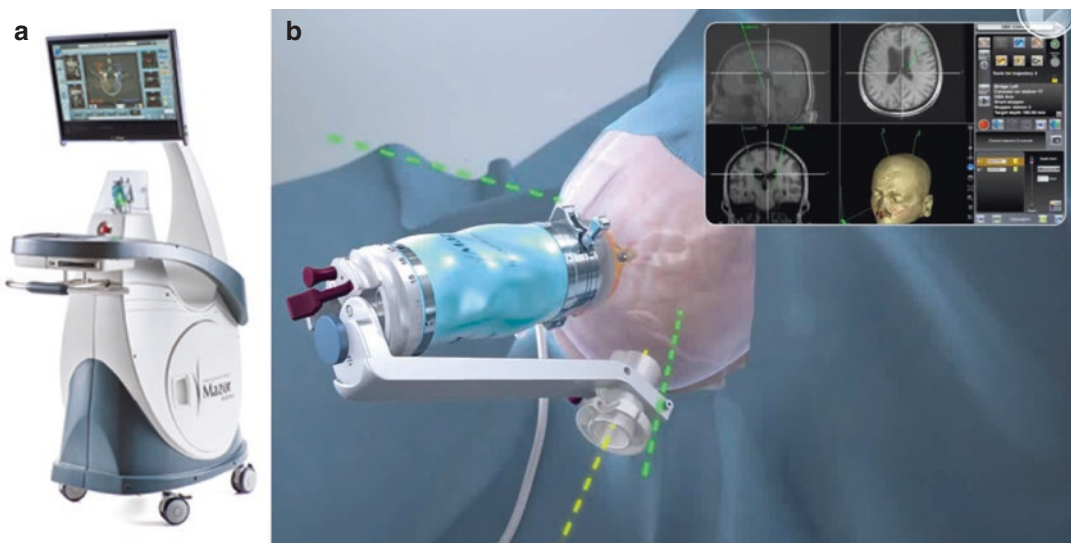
The Renaissance robotic platform robot gained FDA approval for cranial surgery in 2012. (a) The Renaissance robotic platform provides its own software which can be used to co-register preoperative imaging with an intraoperative CT scan. (b) A small reference frame is affixed to the patient's skull, and then a guidance
